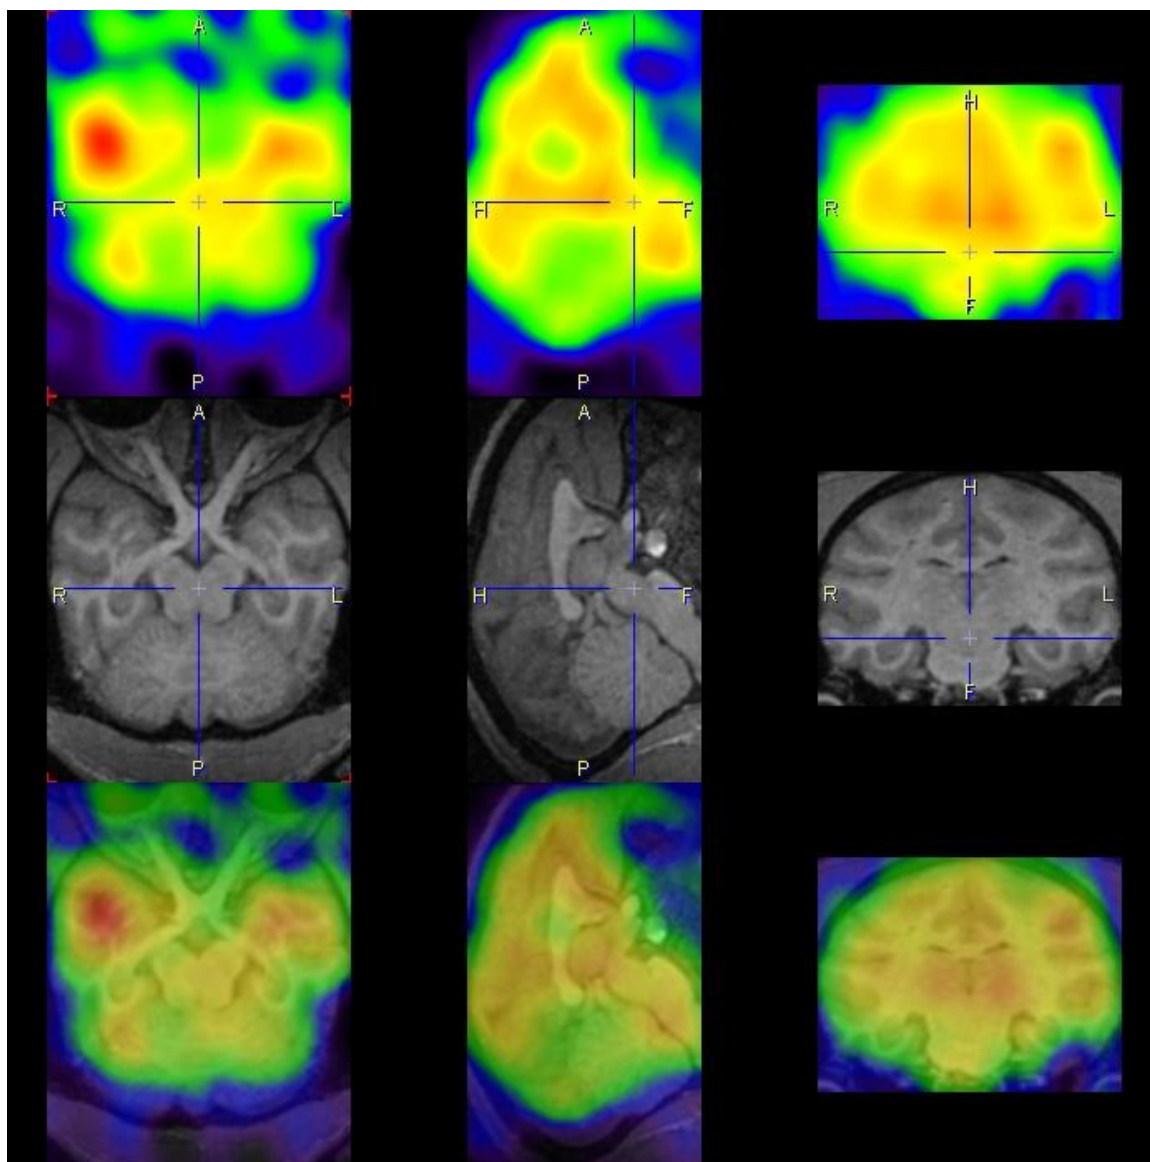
Brain SPECT images showing the distribution of $^{123}\text{I-NKJ64}$ in baboon 2.
